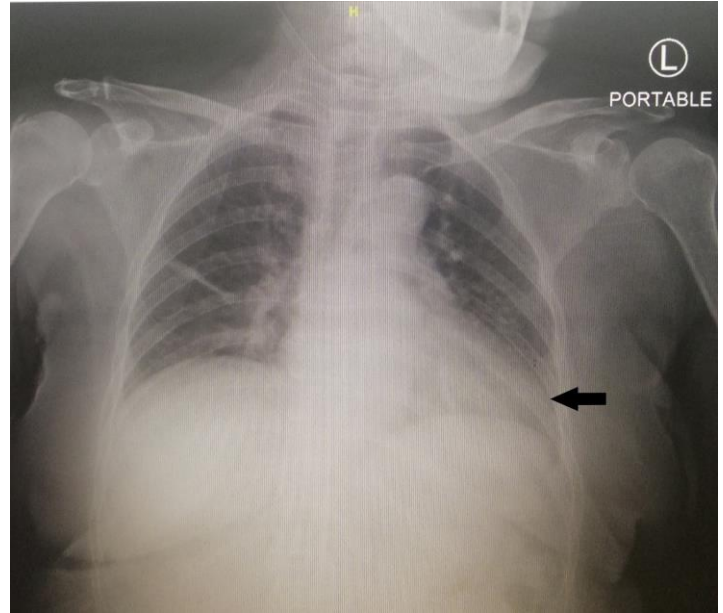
Anterior-posterior view of chest X-ray show atelectasis of the left lower zone of the lung with consolidation (arrow).
